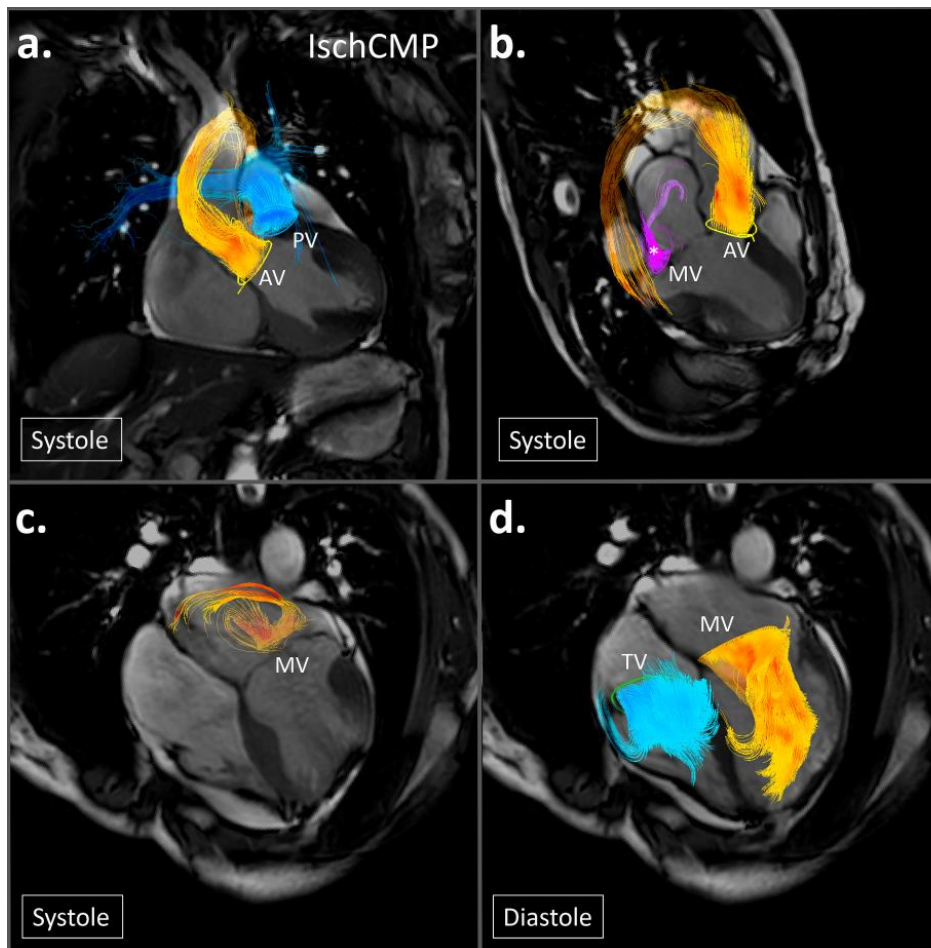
Automated valve tracking in a patient with ischemic cardiomyopathy (IschCMP) with streamlines projected on cine MRI views. (a) Aortic and pulmonary outflow during systole, (b) aortic outflow and mitral regurgitation during systole. * Mitral regurgitation is shown in purple instead of yellow/orange (i.e. the setting of post processing software) because of the overlap with aortic outflow. (c) mitral regurgitation during systole on a standard four-chamber cross-sectional view, (d) mitral and tricuspid inflow on the same four-chamber view.
